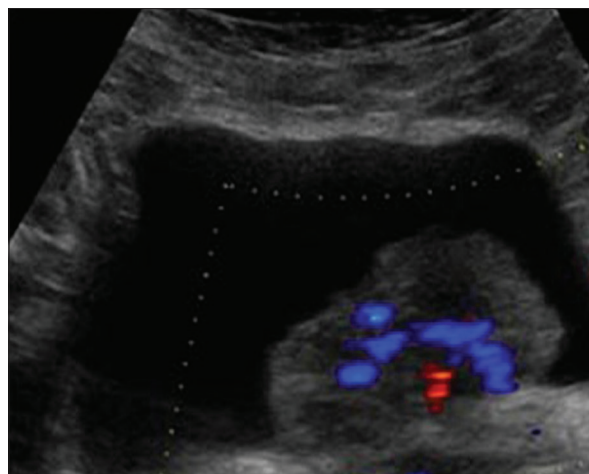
Doppler ultrasound image showing vascular bladder mass
